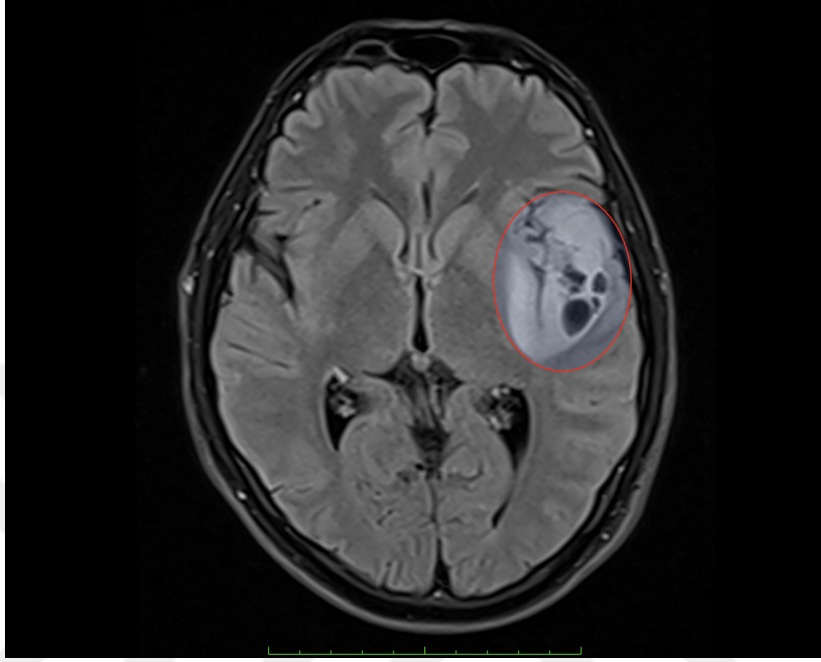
A real LGG instance obtained using MRI data located in white matter
